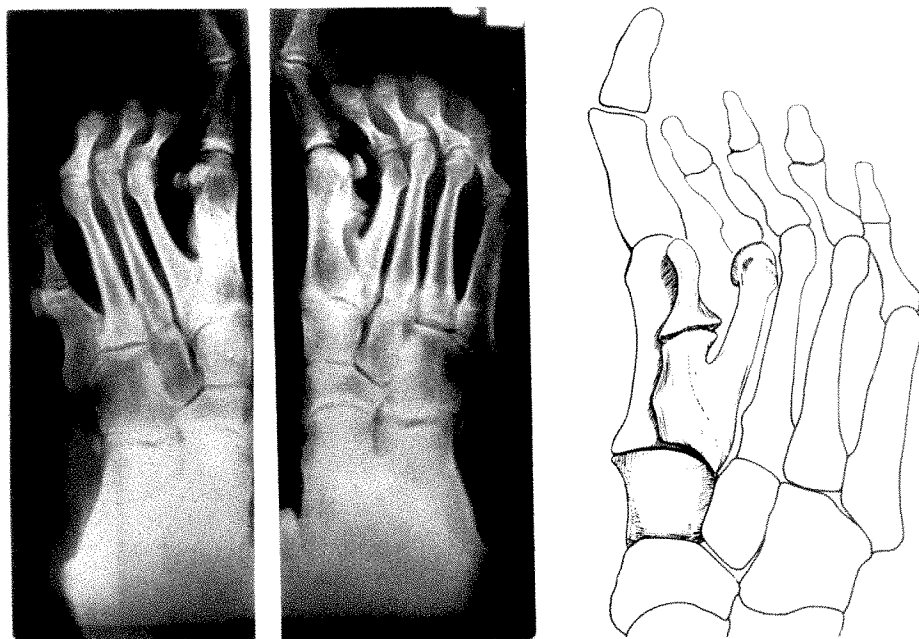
The x-ray findings and their interpretation in the case of the propositus, III-1.
